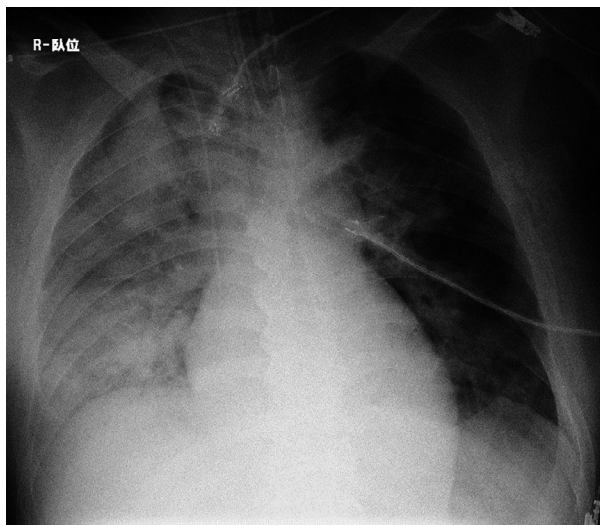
Chest radiograph of a 40-year-old man with acute mitral valve regurgitation on day 2 of hospitalization. Right-sided infiltration worsened compared to day 1.
